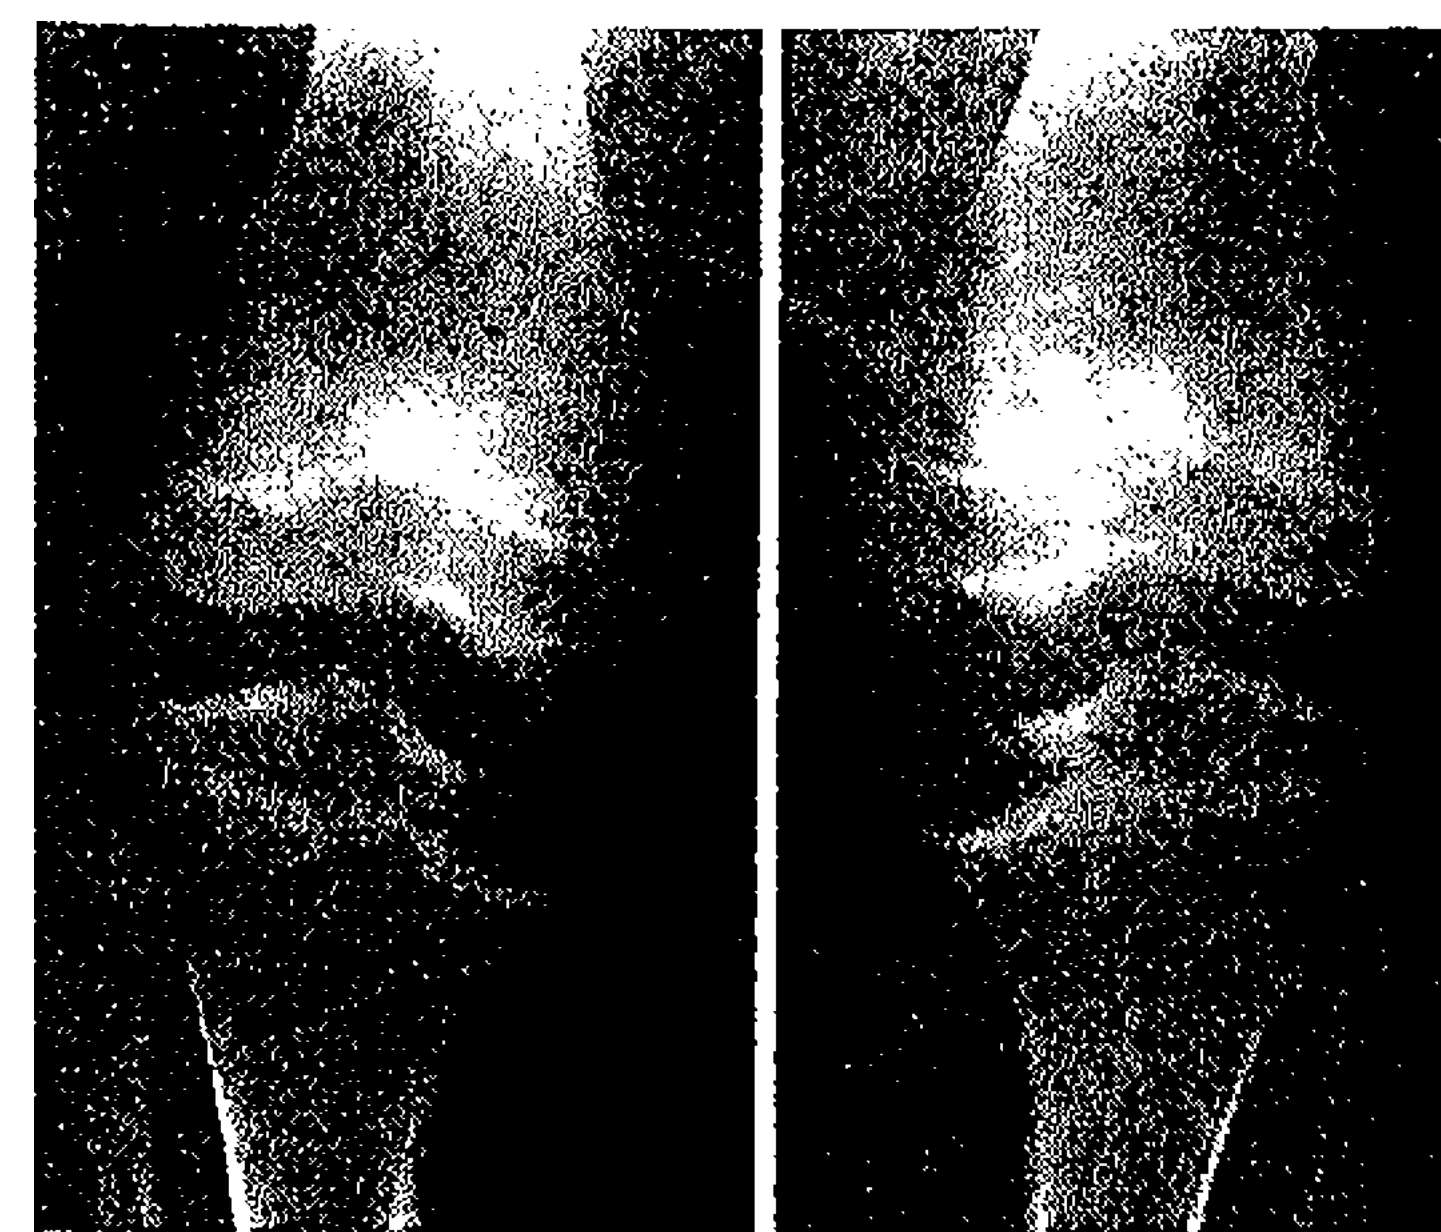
X-rays of the right and left knee joints of an 11 years 9 months old affected boy in the Dutch family. Note irregular ossification and flattening of epiphyses.
